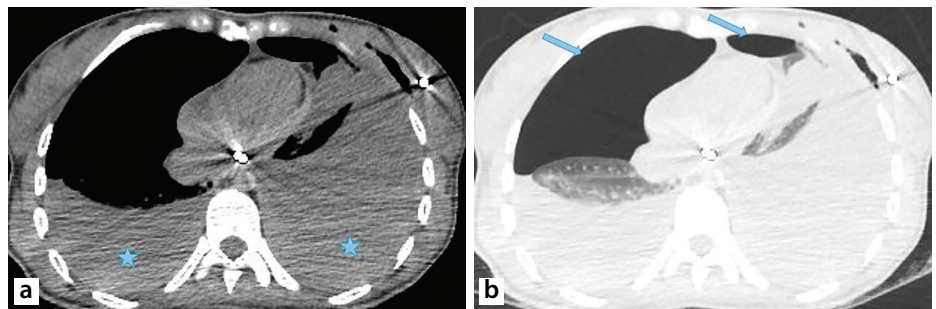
A 35-year-old Syrian woman with gunshot wounds was examined postmortem. (a, b) Computed tomography scans revealed metallic foreign bodies in the heart and left breast, bilateral hemothorax (stars), and bilateral pneumothorax (arrows), more severe on the right.
